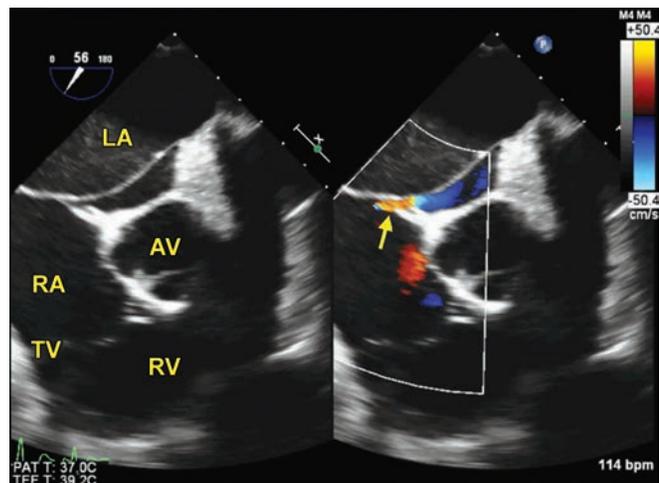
Transesophageal aortic valve short-axis view. Arrow points to a patent foramen ovale.
